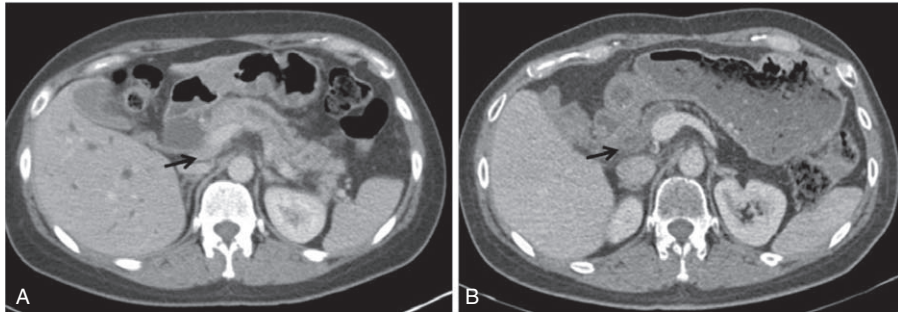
CT images demonstrating the tumor (arrows). (A) Initial staging scan. (B) Scan after chemoradiotherapy demonstrating tumor regression.
